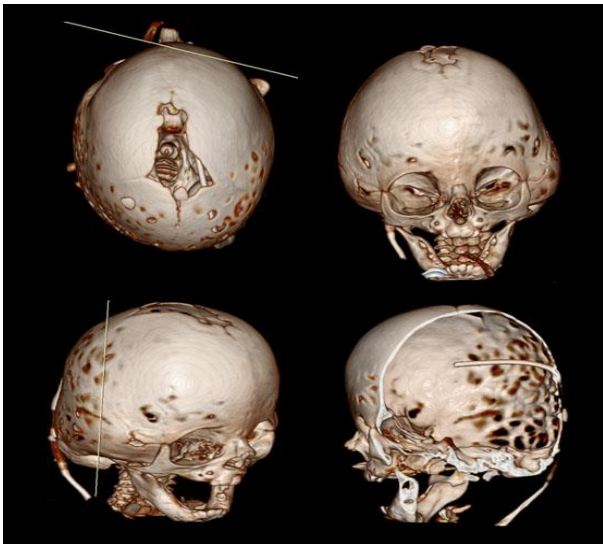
Preoperative CT three-dimensional bone reconstruction showing complex head deformity and position of the ventricular catheter and valve
